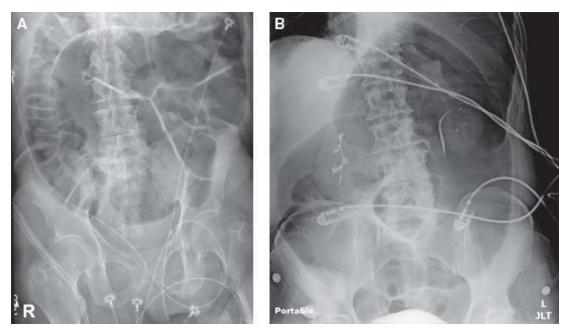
A: Supine abdominal radiograph showing sigmoid volvulus demonstrating a dilated loop of large bowel within the midabdomen with multiple folds pointing toward the right upper quadrant. Proximally, gas-filled loops of cecum and ascending colon are present. B: Supine abdominal radiograph showing cecal volvulus demonstrates dilated, gas-filled cecum within the left upper quadrant. Note that the large bowel emanates from the right lower quadrant, with gas seen distally in the sigmoid colon.
